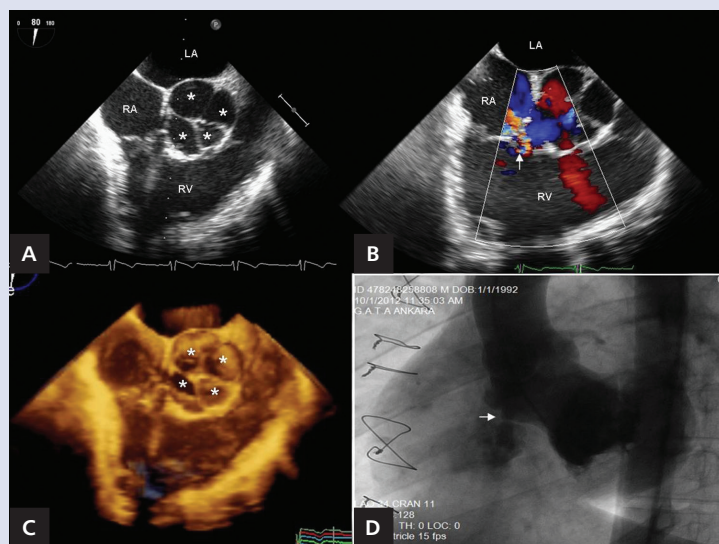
Two- and three-dimensional transoesophageal echocardiography (2D and 3D TEE) revealed the aortic valve consisted of 4 leaflets of differing sizes (A). 2D colour Doppler TEE displayed a mild aortic regurgitation and a ventricular septal defect (B). 3D TEE full volume view also revealed quadricuspid aortic valve (C). Left ventriculography demonstrated a membranous ventricular septal defect (D); LA — left atrium; RA — right atrium; RV — right ventricle; asterisk — aortic cusps; arrow — ventricular septal defect
